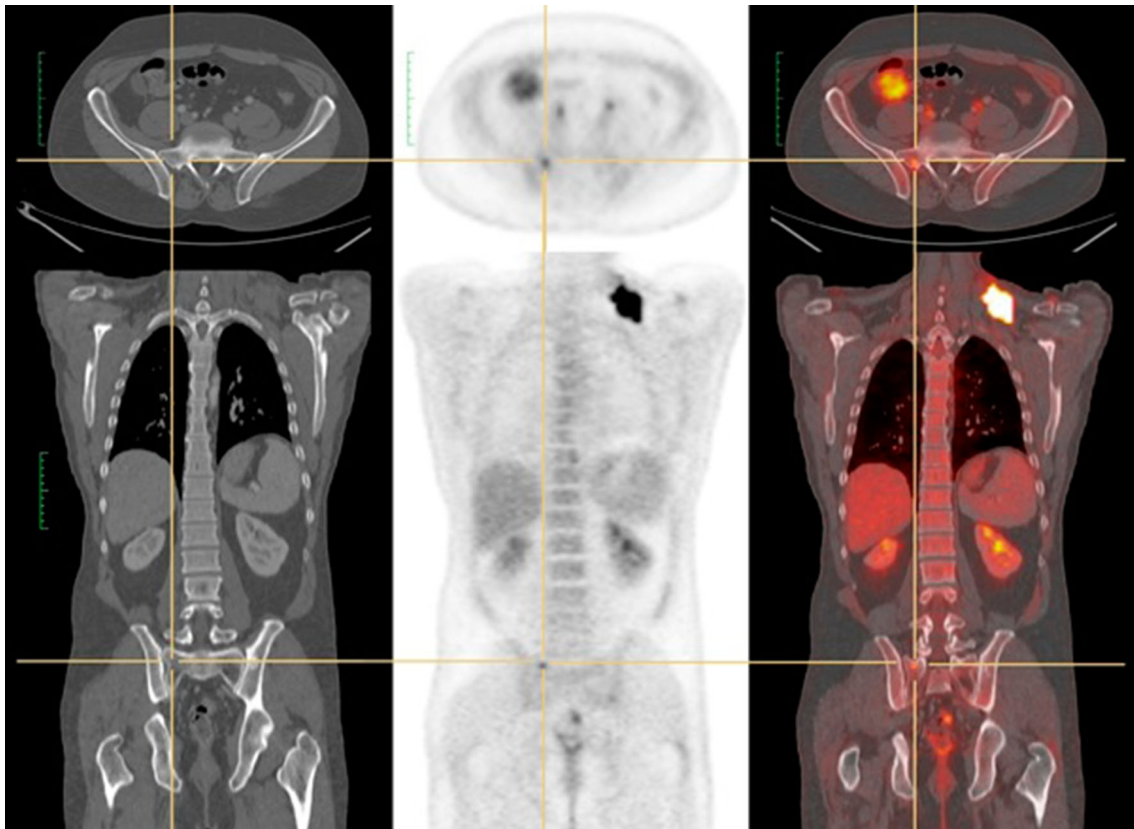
Bone metastasis at initial staging of a nasopharyngeal squamous cell carcinoma detected by ^{18}F -FDG PET/CT. The bone lesion was not detected by conventional imaging. In this case, the PET/CT changed the management
